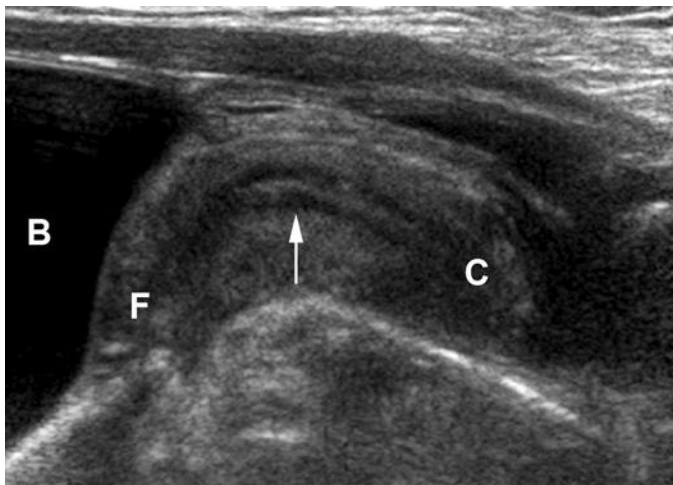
Normal neonatal uterus. Sagittal ultrasound image shows a prominent uterine fundus (F) with echogenic endometrium surrounded by a hypoechoic halo (arrow). B, bladder; C, cervix.
